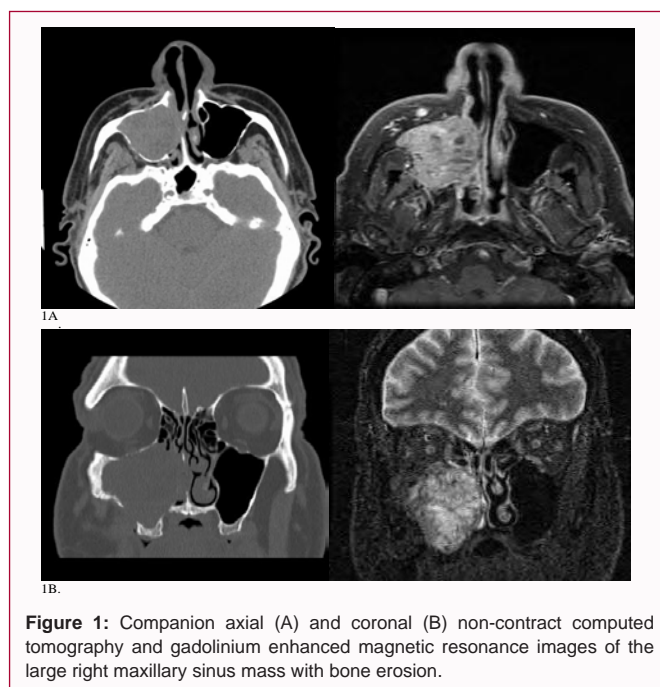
Companion axial (A) and coronal (B) non-contrast computed tomography and gadolinium enhanced magnetic resonance images of the large right maxillary sinus mass with bone erosion.
